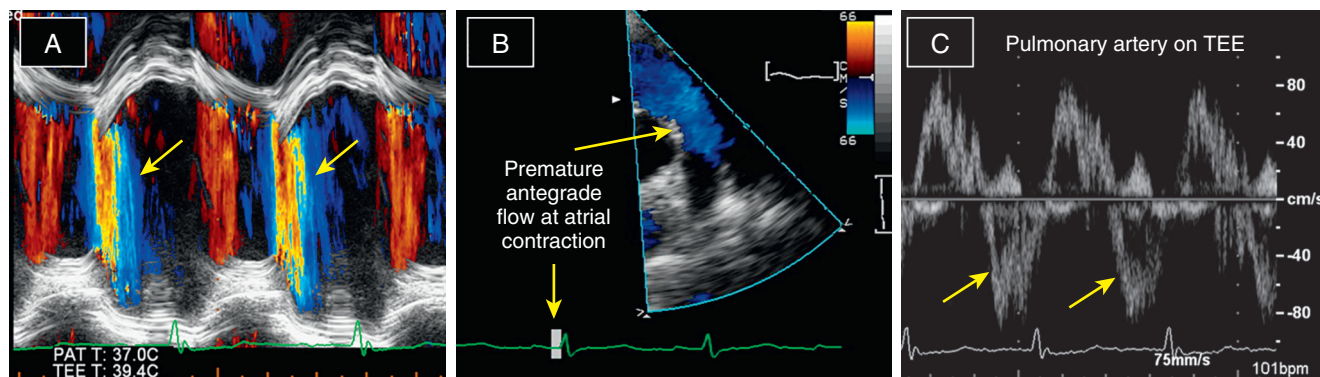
Additional markers of severe pulmonic regurgitation. A, Color M mode demonstrates that pulmonic regurgitation (PR) jet terminates abnormally in early diastole (arrows). This is in contrast to less severe forms of PR, where the PR jet lasts throughout diastole. B, Color Doppler on transthoracic short-axis view at the level of the aortic valve demonstrates abnormal antegrade flow across the pulmonic valve at the time of atrial contraction indicative of premature pulmonic valve opening resulting from elevated right ventricular pressures in severe PR. C, Transesophageal echocardiography (TEE) spectral Doppler tracing demonstrates abnormal holodiastolic flow reversal (arrows) in the pulmonary artery indicative of severe PR.
